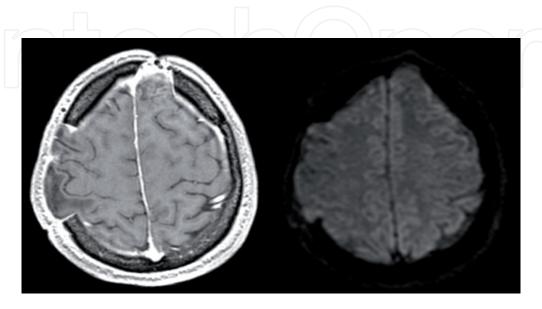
Post-operative contrast enhanced T1 scan (left image) showing a significant decrease in contrast enhancement; Craniectomy site on the right fronto-temporal region and a burr hole on the left frontal region can be seen. DWI scans show no diffusion restriction.
